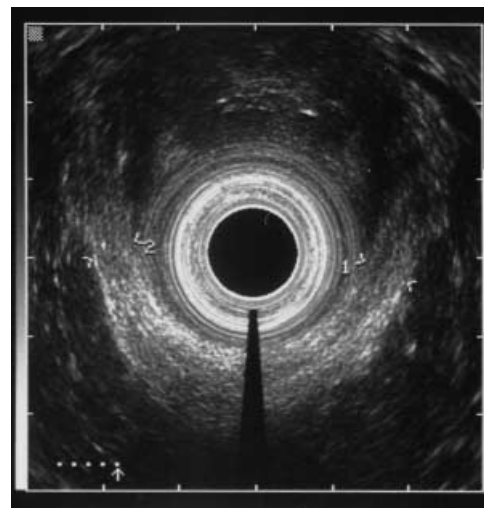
Puborectal muscle (hyperechoic structure) as seen by endoanal ultrasound. The sling wraps around the posterior aspect of the rectum. Muscle thickness is measured on both sides with a mean value of 6.4 mm in this patient
